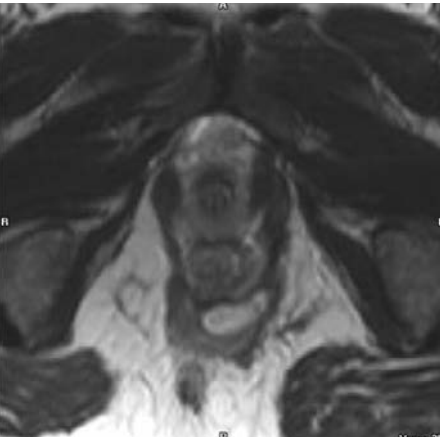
Axial T1-weighted image. Perianal fistula with an ischioanal fossal abscess
